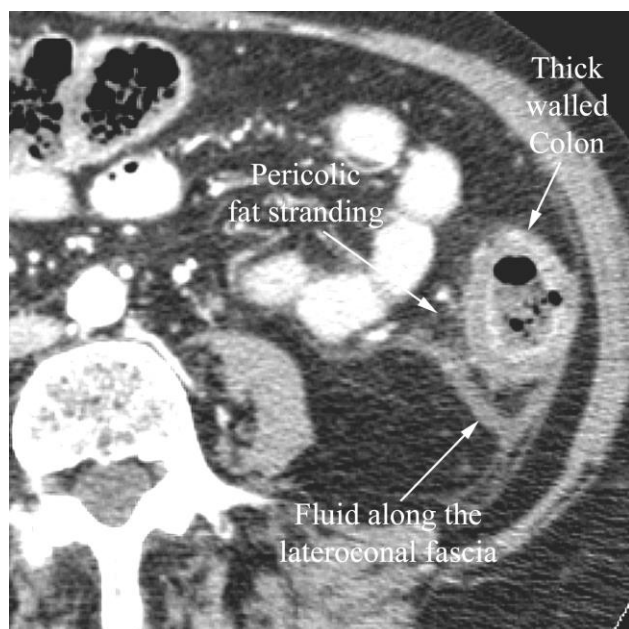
Pseudomembranous colitis in an 88 year old woman with diarrhea following antibiotic treatment. CT demonstrates a thick walled colon and pericolic fat stranding as well as fluid along the lateroconal fascia.
